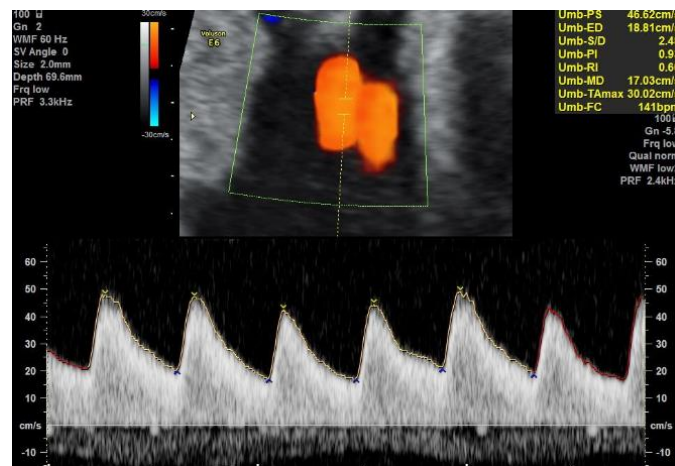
Insonation and obtention of the flow velocity wave of the umbilical artery. Observe the insonation angle close to 0°, the optimization of the colour scale to avoid aliasing and the adjustment of the velocity scale, aiming for the wave to fill 75% of the Doppler screen.
